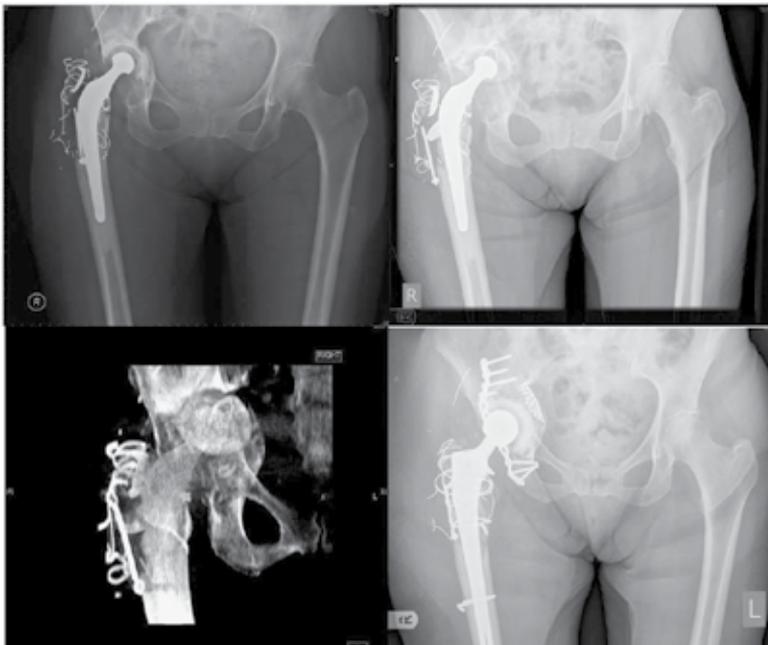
Top left & right, Progressive acetabular osteolysis over 1.5 years, Bottom left, 3D CT reconstruction demonstrating lesion and pelvic discontinuity, Bottom right, defect reconstructed with mesh and bone graft and plate to posterior column to address discontinuity
